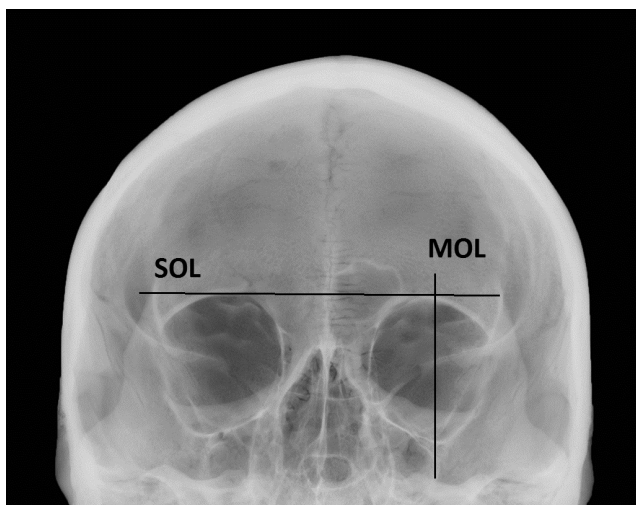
Roentgenogram of the skull with a metopic suture showing right side aplasia and left side sinus of medium size. Abbreviations: SOL – supraorbital line; MOL – midorbital line
